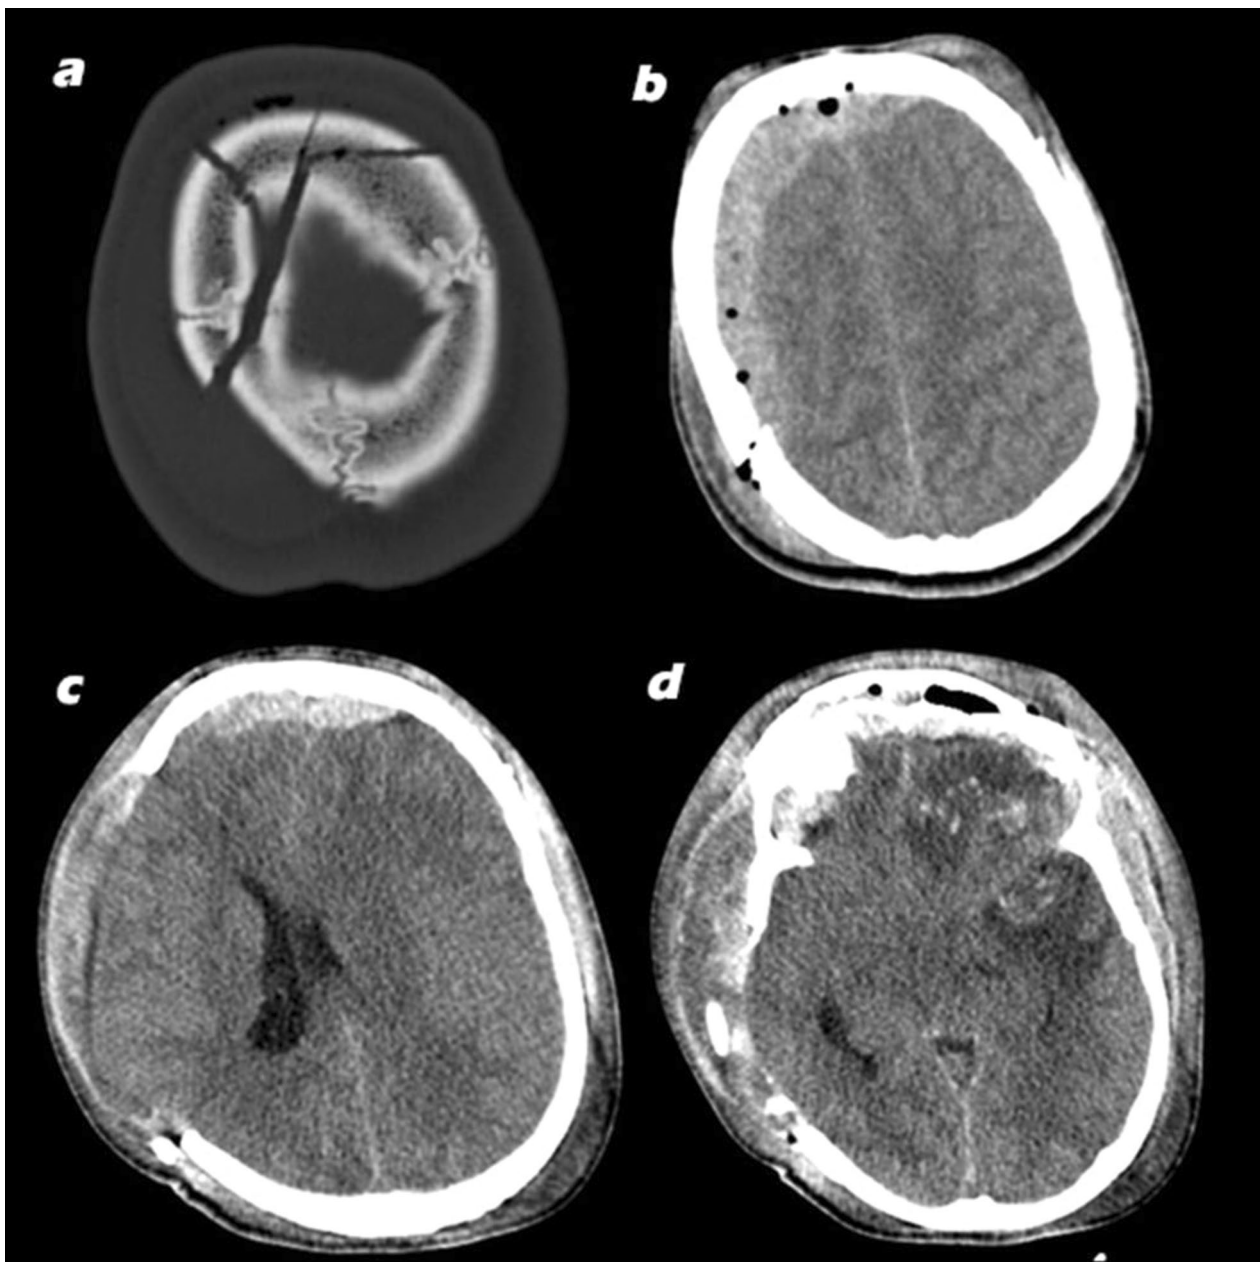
a Fracture of right parietal bone extending through coronal suture to bilateral frontal bones; b extra-axial hematoma extending from midline, mainly on right side with pneumocephalus; c CT after decompressive craniectomy showing edema; d left frontotemporal contusions with edema
